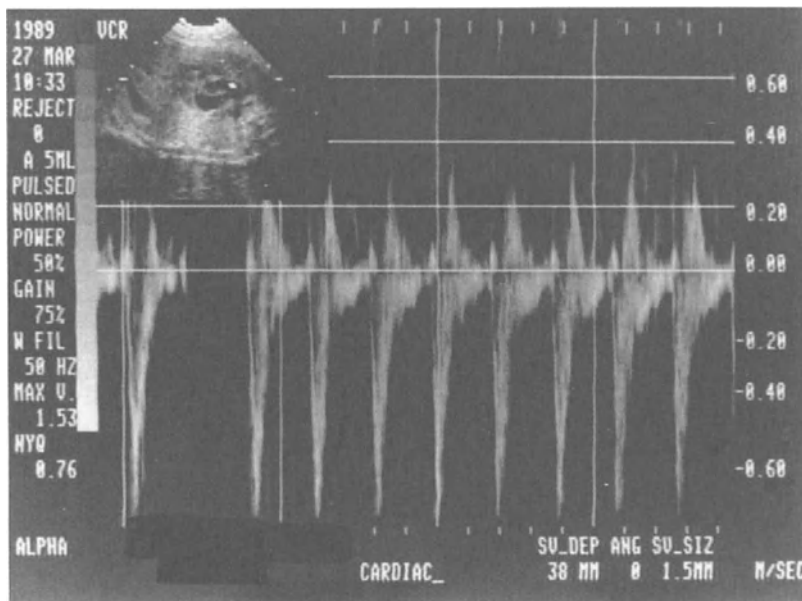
Doppler frequency shift waveforms from the ascending aorta. Note the steep slopes and the sharp peak of the waveform.
